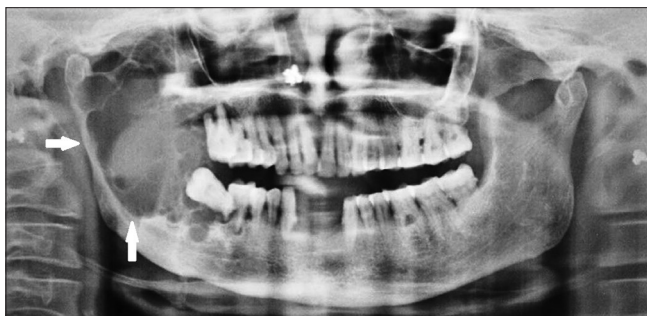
Orthopantomograph showing a multilocular lesion over the right side of the mandible causing expansion and thinning of the cortical plates extending from the body of the mandible to involve the entire ramus
